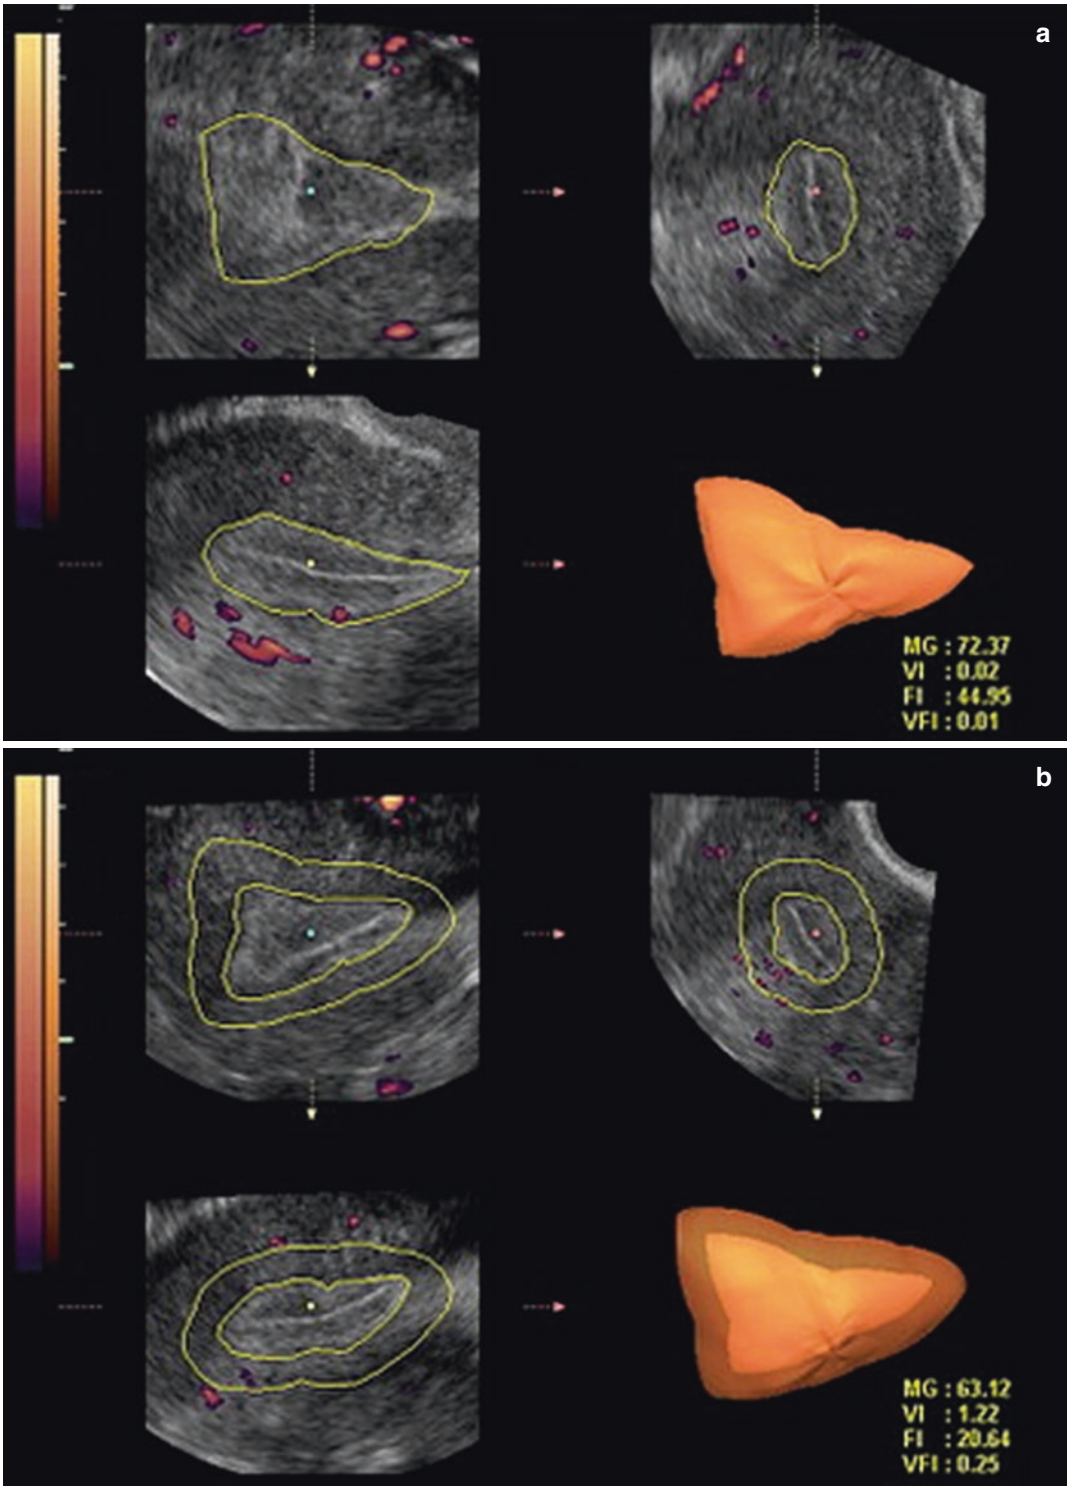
Three-dimensional power Doppler images generated using VOCAL software. (a) Endometrial. (b) Subendometrial blood flow parameters on the day of IUI.
